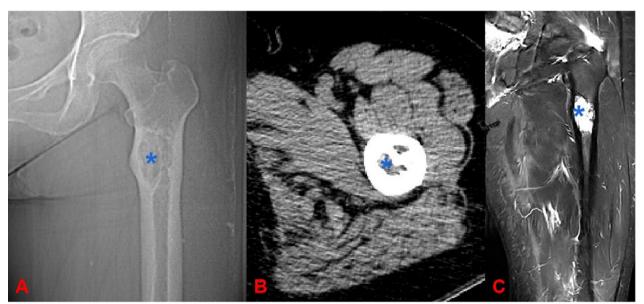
The radiographic results of Patient 1. A The preoperative anteroposterior X-ray showed a ground-glass appearance (blue asterisk) of the left proximal femur bone. B The preoperative transverse computed tomography image showed the appearance of a lesion site in the marrow cavity of the proximal femur bone (blue asterisk). C The preoperative transverse T2-weighted (magnetic resonance imaging) image showed high intensity in the medullary space of the left proximal femur bone (blue asterisk)
